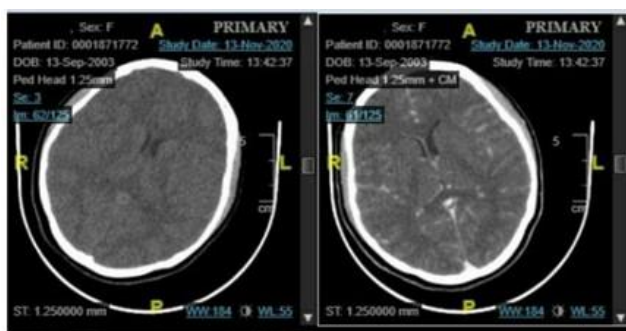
Head CT Scan of the patient showed narrowing cortical sulci in fronto-temporo-parieto-occipital lobe and right sylvian fissure, suspected cerebral edema.
